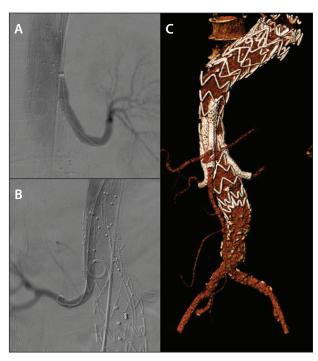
Perioperative angiogram (A, B) and CT scan at 1 month (C).
